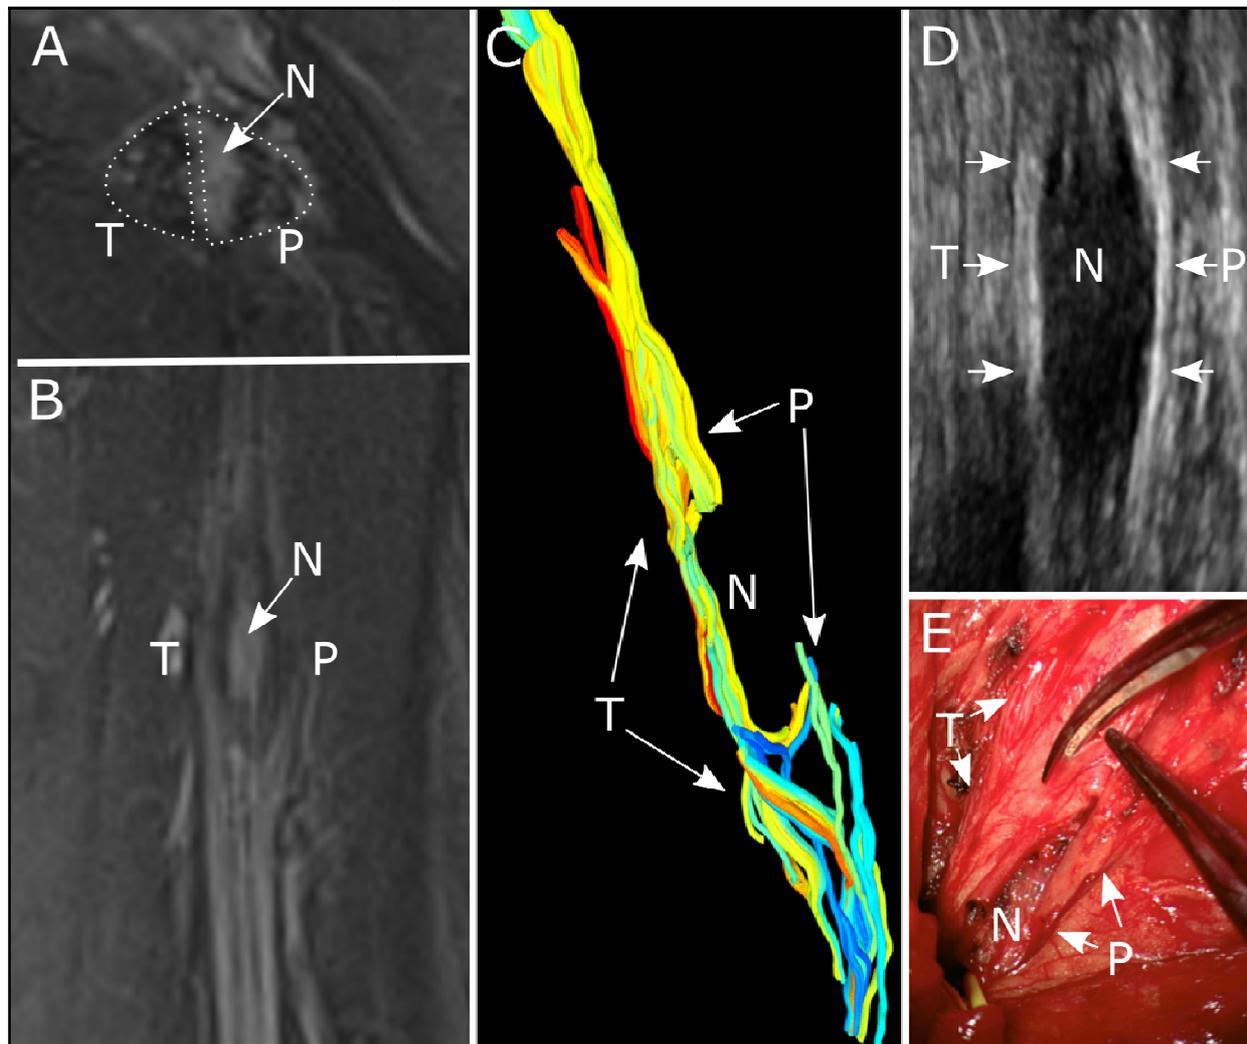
Complementary nature of ultrasound and MRI. Axial and coronal T2 fat saturated images (A and B) of the sciatic nerve after a gun-shot injury to the thigh with a relatively intact appearance of the tibial component (T), but hyperintensity and loss of fascicular structure in the common peroneal component (P). There has been complete loss of the fibers comprising the medial aspect of the common peroneal component with subsequent neuroma formation (N), which appears as confluent T2 hyperintensity. The extent of intact common peroneal fibers is difficult to assess with traditional MRN. DTI tractography (C) suggests a complete discontinuity of the common peroneal fibers at the site of injury. However, high-resolution ultrasound (D) is able to distinguish some remaining intact common peroneal fibers. Surgical exploration confirmed the ultrasound findings (E).
